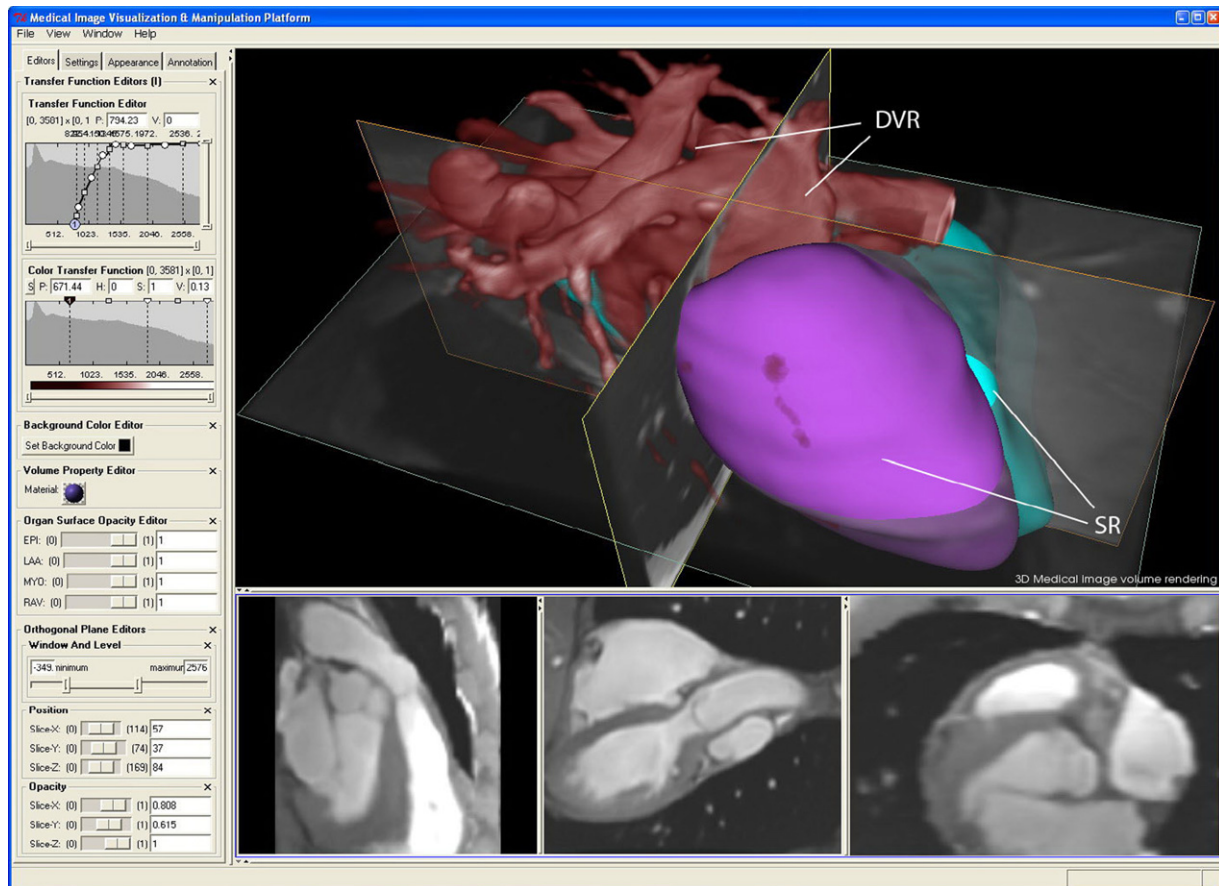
3D CT cardiac dataset are volume rendered with colored surfaces for FOI enhancement. Transfer functions, clipping plane, orthogonal plane with corresponding 2D slice views, and windows-level editor are designed for volume manipulation.
